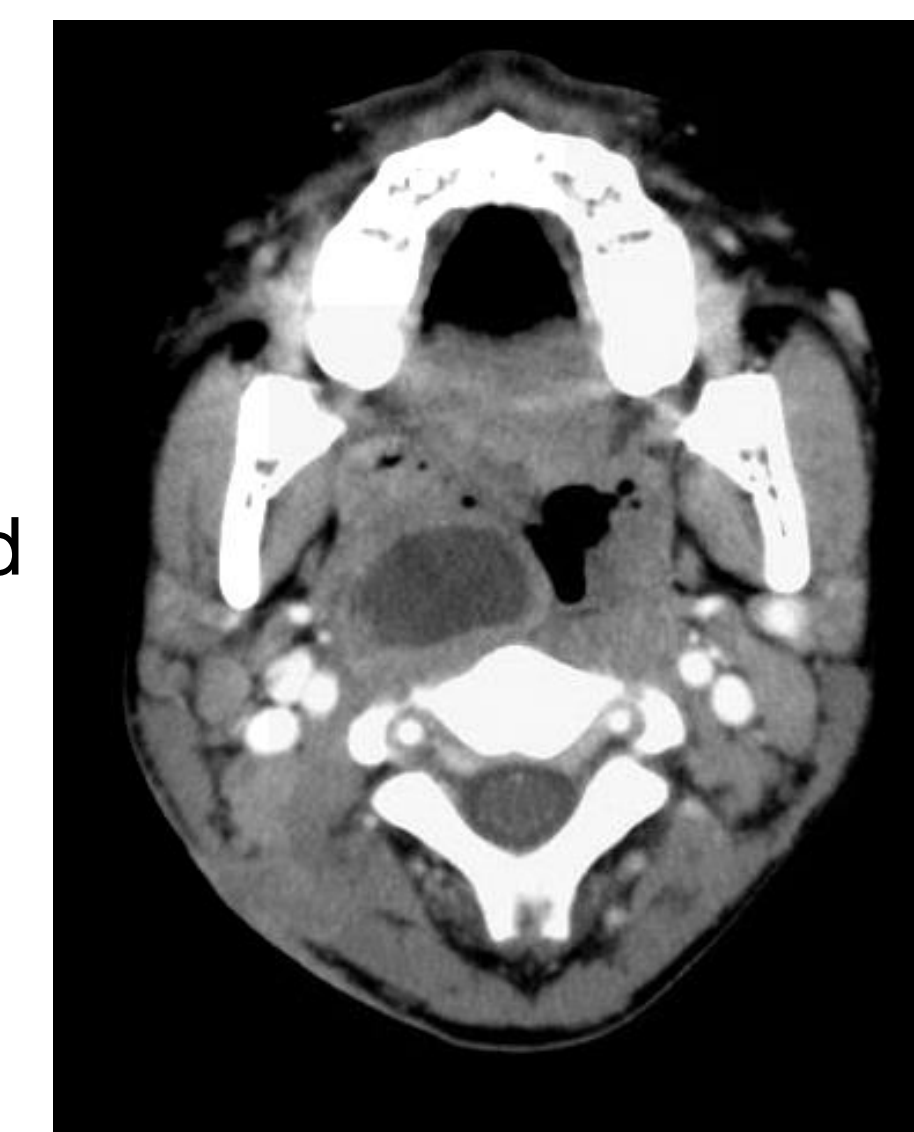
(left). CT image with large right retropharyngeal abscess and necrotic nodes in jugular chain, reactive lymph nodes in cervical chain, and chronic overlying cellulitis
